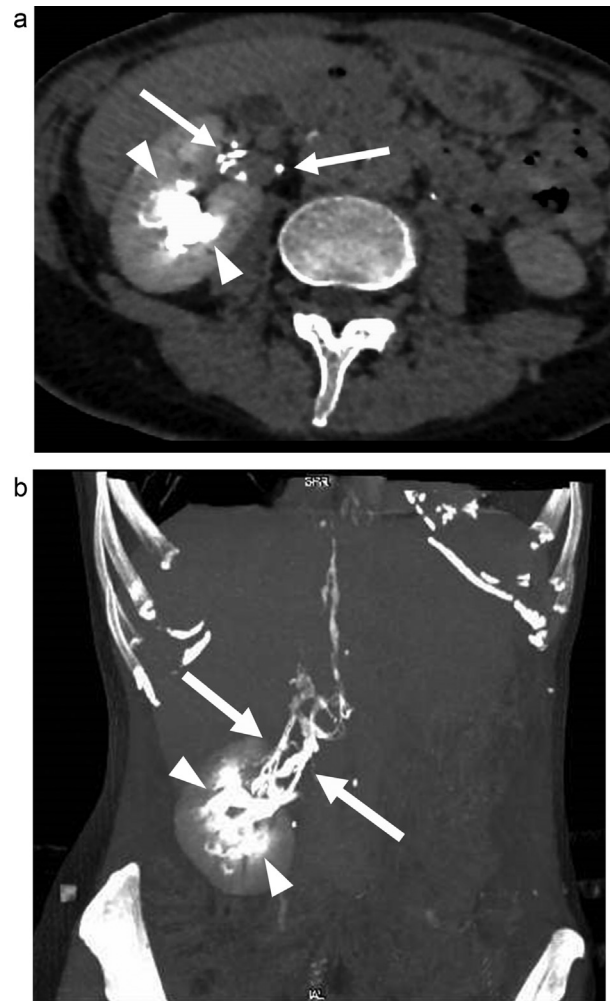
A delayed phase of contrast-enhanced computed tomography scan (A: axial view, B: coronal view) showed thin lymph vessels (arrows) at the right renal hilum, suggesting communication between the right urinary system and the lymph system. Arrowheads indicate dilated renal calyx and pelvis.
